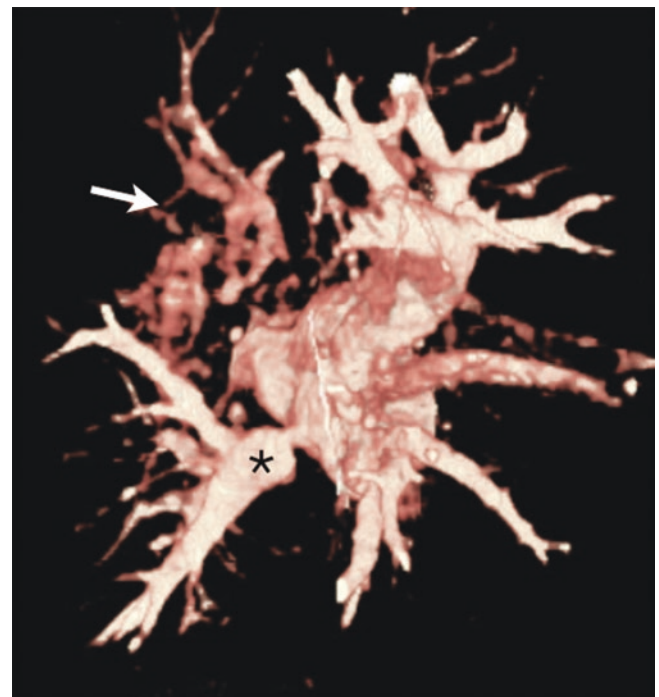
Pulmonary vein stenosis in a 9-month-old, contrast-enhanced CT. 3D volume-rendered image, viewed from posterior, of the pulmonary veins showing a discrete left lower pulmonary vein stenosis (*). The arrow shows the faint outline of the peripheral left upper pulmonary veins due to complete occlusion of the left upper pulmonary vein
